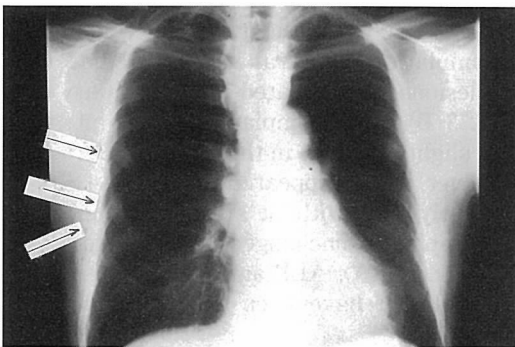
Follow up chest radiography 4 weeks later showed callus formations of the right IV, V, VI and left ribs (→) with residual infiltrate in the middle lobe.
